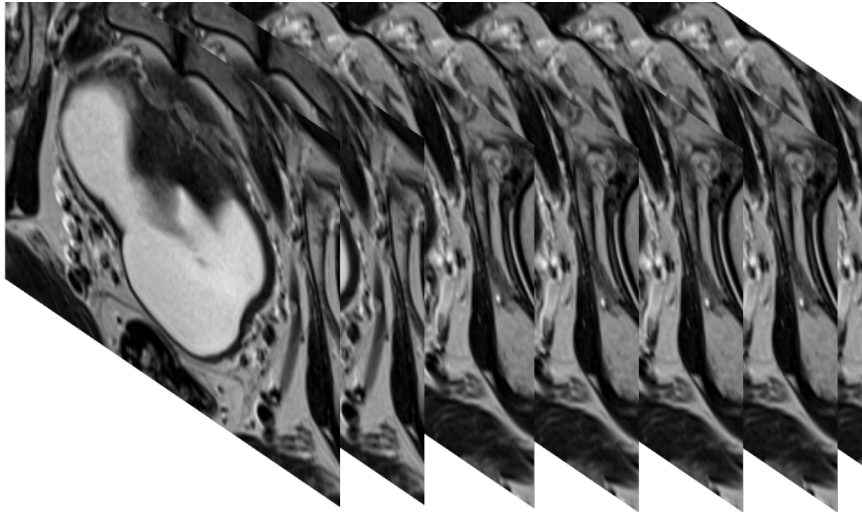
MRI's slices for a specific patient
